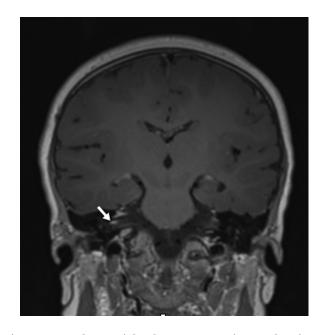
Coronal T1-weighted post contrast image showing abnormal enhancement along the canalicular component of the right seventh cranial nerve extending to the first genu (white arrow)
